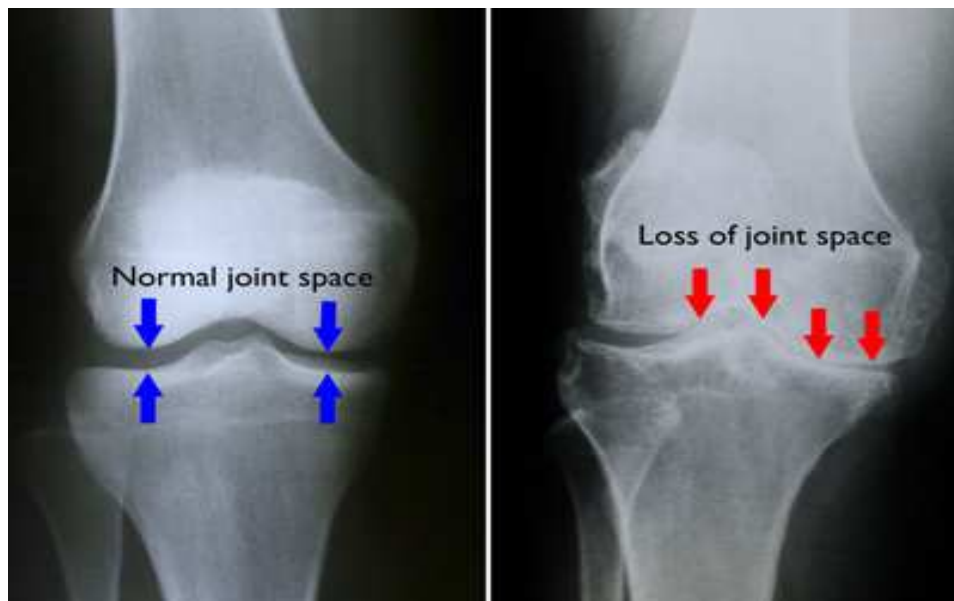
Radiographic joint space narrowing
